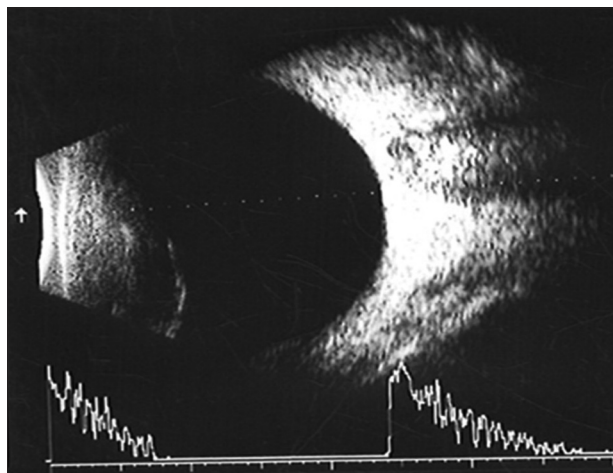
Sonogram of the right eye of a 70-year-old female demonstrating cataract with normal posterior segment
